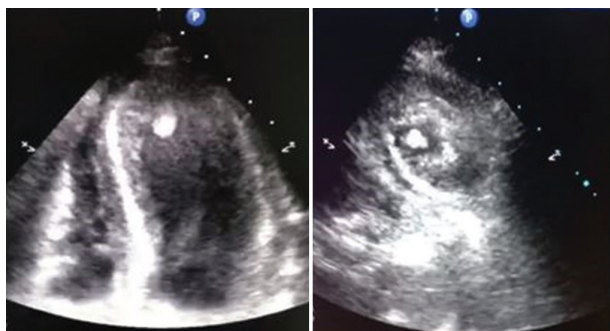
Transthoracic echocardiogram showing apical pedunculated endoventricular thrombus.
